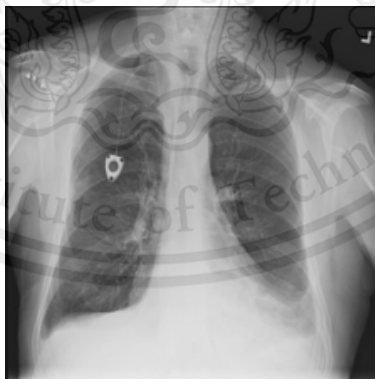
Example of Hernia chest X-Ray image (Wang, Yifan Peng, Le Lu, Zhiyong Lu, & Ronald M. Summers, 2018)
